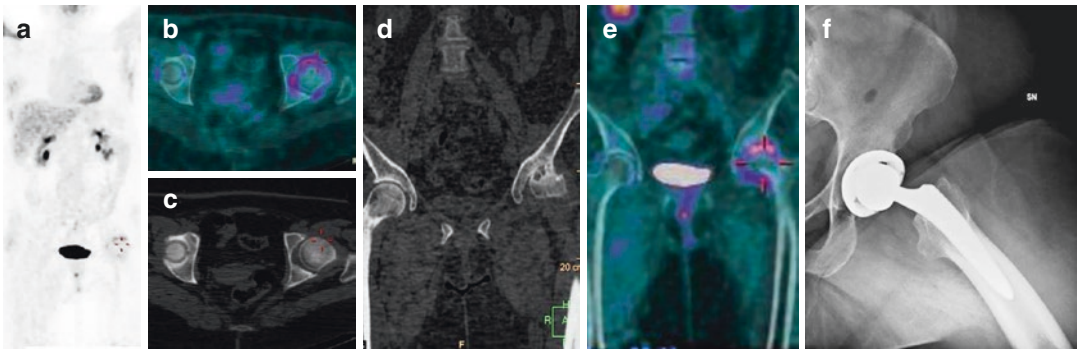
¹⁸F-FDG PET 3D maximum intensity projection (a) shows diffuse uptake surrounding the head of left femur, due to inflammation, as evident in corresponding axial (b, c) and coronal (d, e) CT and PET/CT views. In
